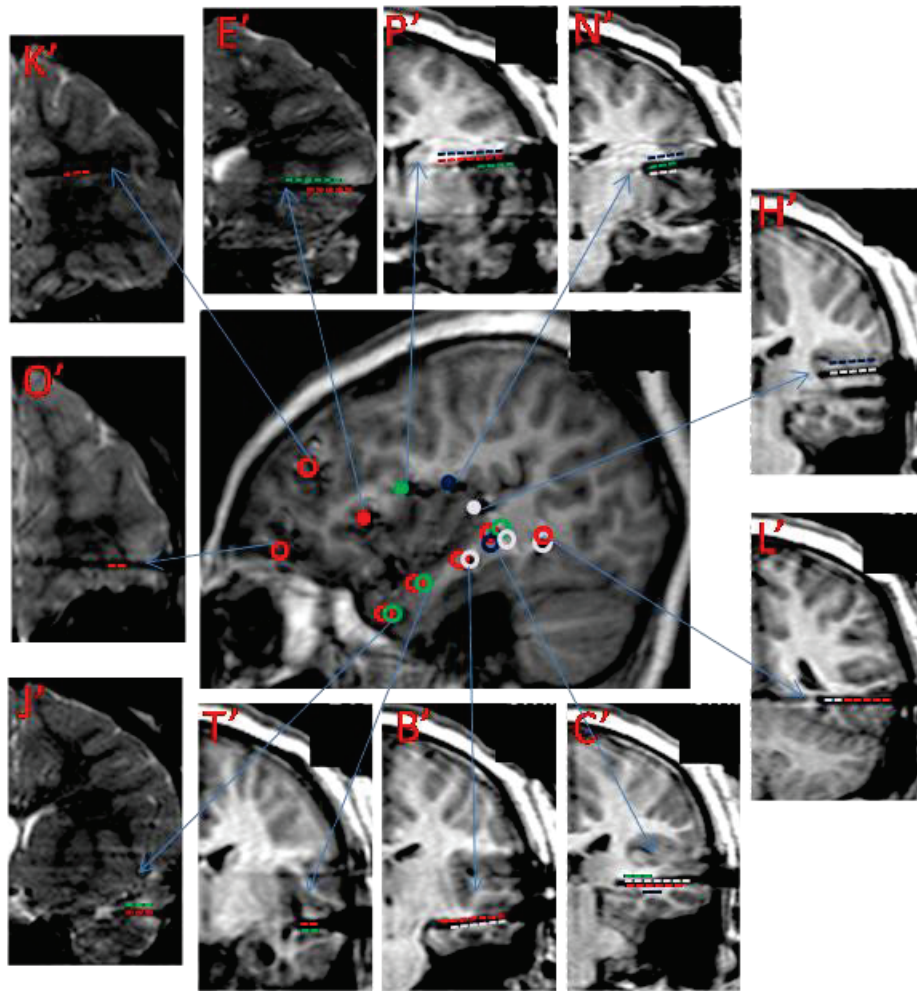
7: Patient 7 MRI with electrodes in place (Left hemisphere). Central sagittal image: each insular electrode is represented by a unique colored solid circle; non-insular electrodes are represented by empty circles with the color of each of the insular electrode they are responding to. Yellow solid circles are for non responding electrodes. Peripheral coronal images: a cross-section of each electrode with its name and its responding contacts (responses are indicated by color coded dotted lines, representing the color of the corresponding stimulated insular electrode).
